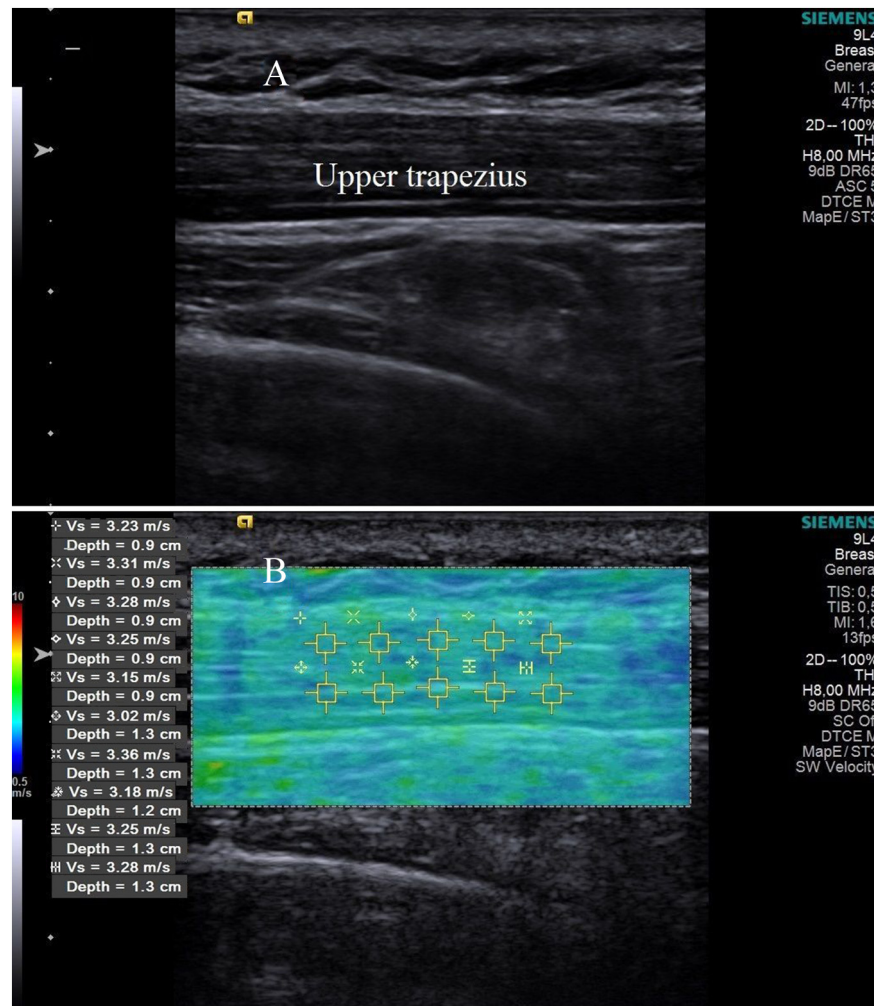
Two-dimensional ultrasound image of the upper trapezius muscle (A). Color map shear wave elastography image of the upper trapezius muscle in the longitudinal plane (B). Ranges of image were placed in the muscle, and corresponding shear wave velocity (m/sec) values were recorded. The shear wave velocity of the tissues increases in the order of blue-green-red color-coded areas.
